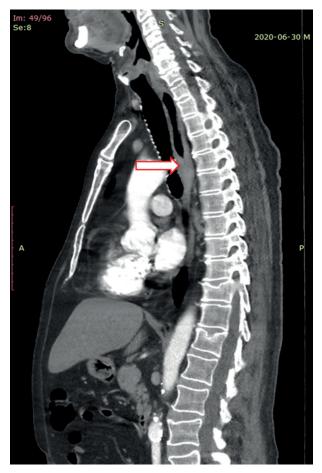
Hydro-computed tomography (CT) image in sagittal reconstructions in a patient with T1/2 esophageal cancer shows the esophageal wall thickening 10 mm in depth with a smooth outer border in the thoracic part of the esophagus
